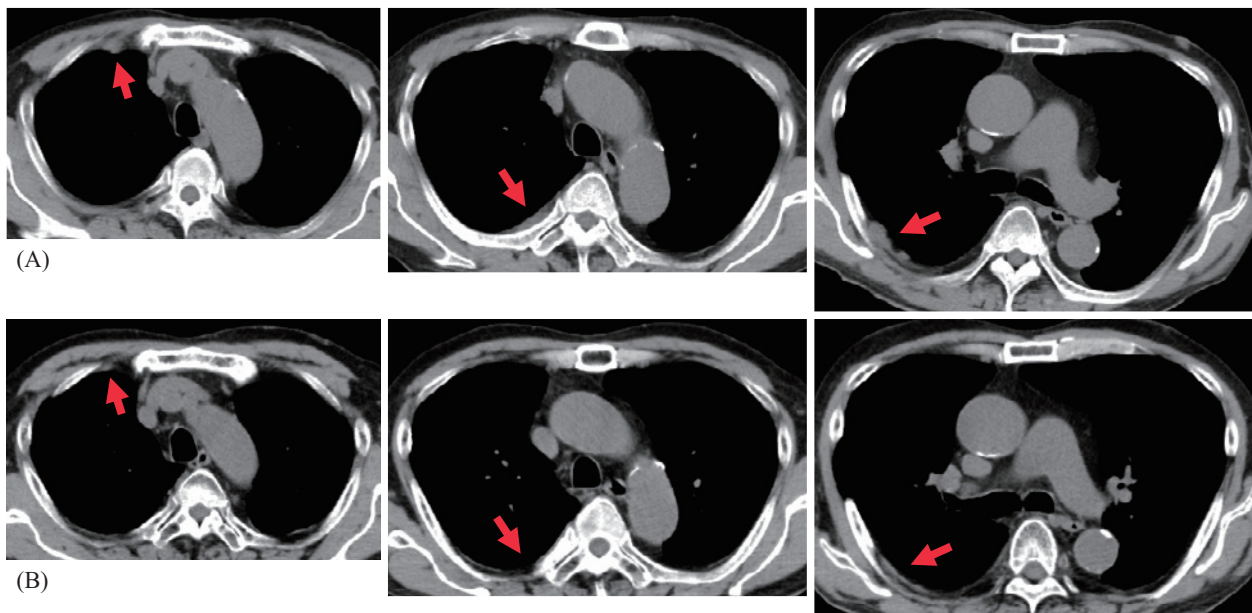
Chest computed tomography scans before (A) and after (B) two cycles of treatment with atezolizumab/bevacizumab/CBDCA/PTX (ABCP therapy).
